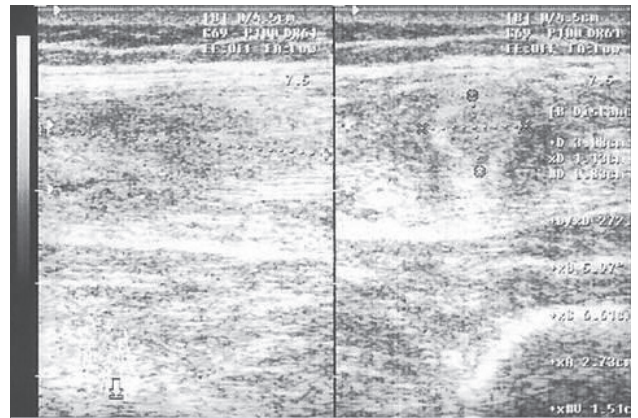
Posttreatment ultrasonographic findings.
